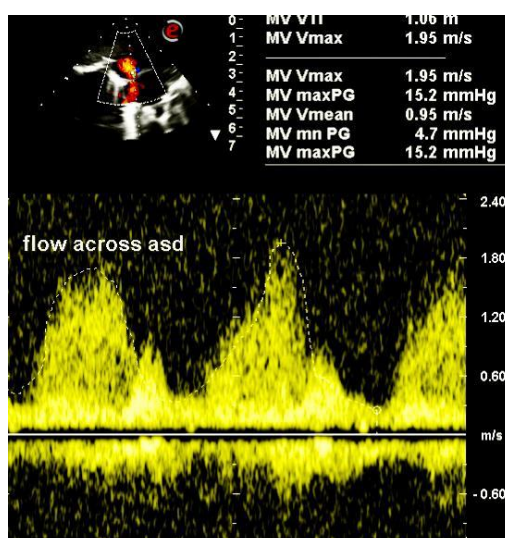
Continuous wave doppler analysis of flow across atrial septal defect. Peak/mean gradient across ASD was 15.2/4.7 mmHg.
